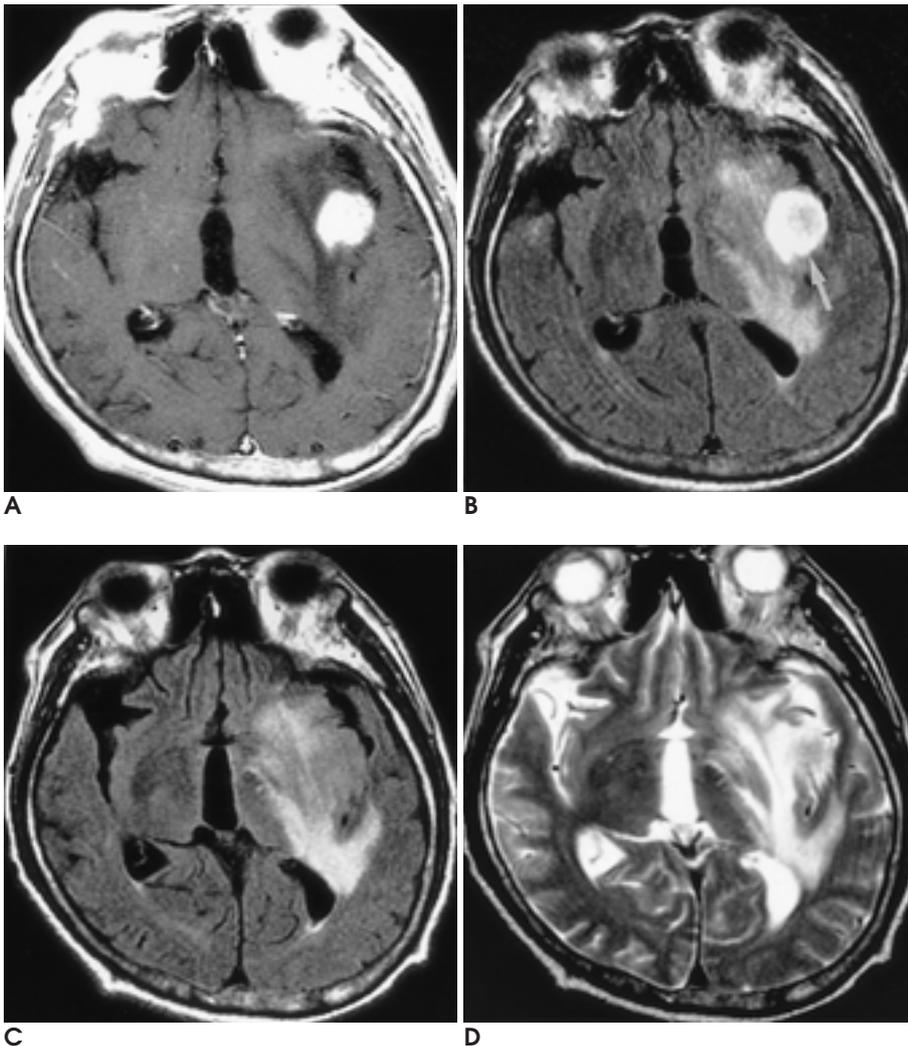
A 69-year-old man with metastasis from small cell lung cancer. Contrast-enhanced T1-weighted (A) and fast FLAIR (B) images show a strongly enhancing mass in the left insula (arrow). Contrast-enhanced fast FLAIR image shows clear distinction between tumor and surrounding edema. The distinction between tumor and edema is not clear on fast FLAIR (C) and T2-weighted (D) images. The conspicuity of tumor is best on contrast-enhanced T1-weighted and it is better on contrast enhanced fast FLAIR than on fast FLAIR or T2-weighted image.
